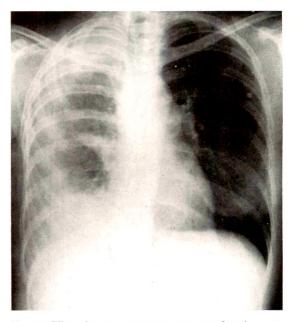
The chest roentgenogram on October 18, 1965 demonstrates pleural thickening and fluid in the right hemithorax, nodules at right and left bases, a prominent pulmonary outflow tract, and calcified hilar and left upper lobe parenchymal densities.
